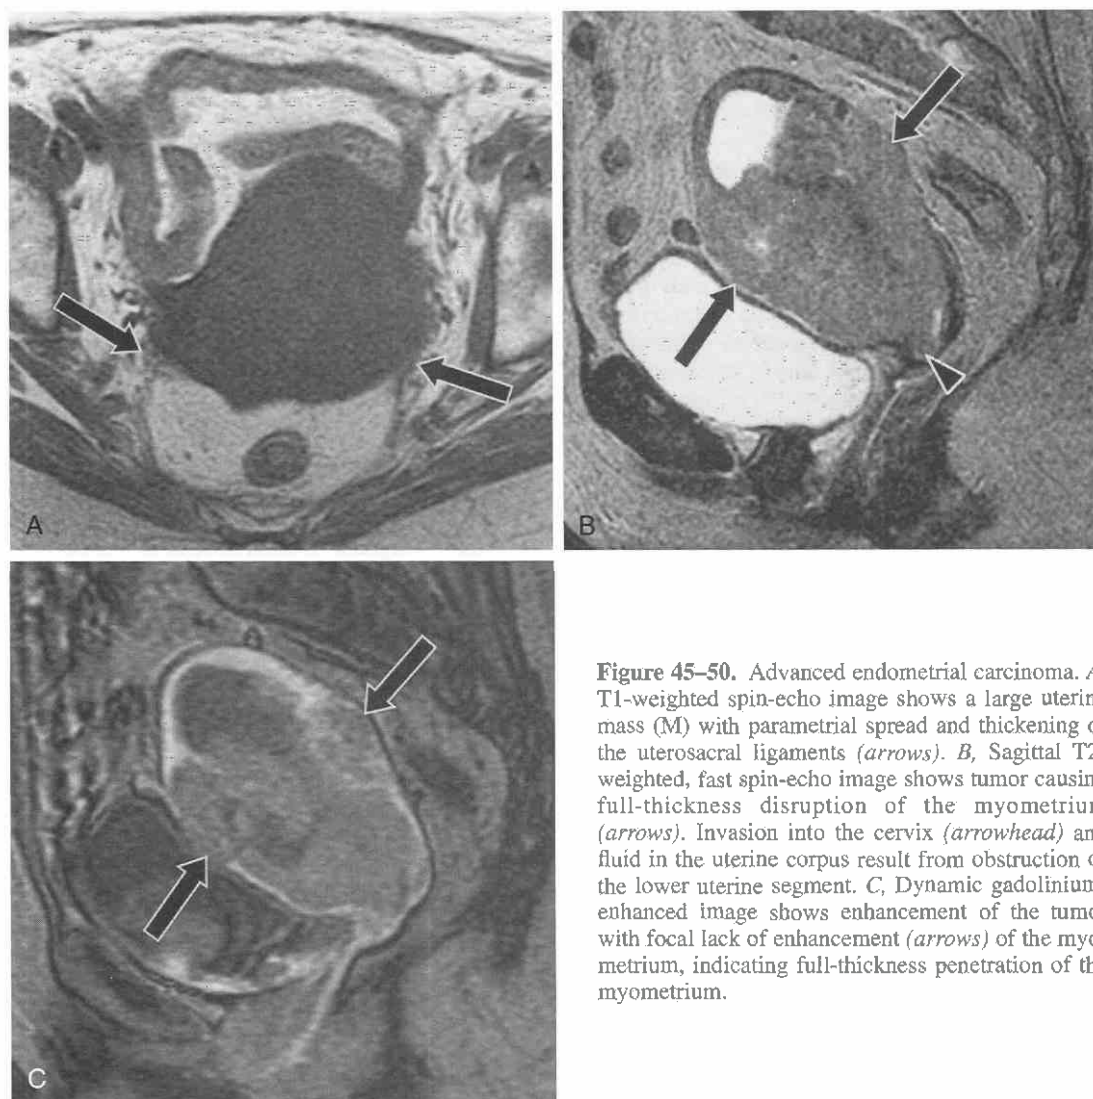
Advanced endometrial carcinoma. *A*, T1-weighted spin-echo image shows a large uterine mass (M) with parametrial spread and thickening of the uterosacral ligaments (arrows). *B*, Sagittal T2-weighted, fast spin-echo image shows tumor causing full-thickness disruption of the myometrium (arrows). Invasion into the cervix (arrowhead) and fluid in the uterine corpus result from obstruction of the lower uterine segment. *C*, Dynamic gadolinium-enhanced image shows enhancement of the tumor with focal lack of enhancement (arrows) of the myometrium, indicating full-thickness penetration of the myometrium.
